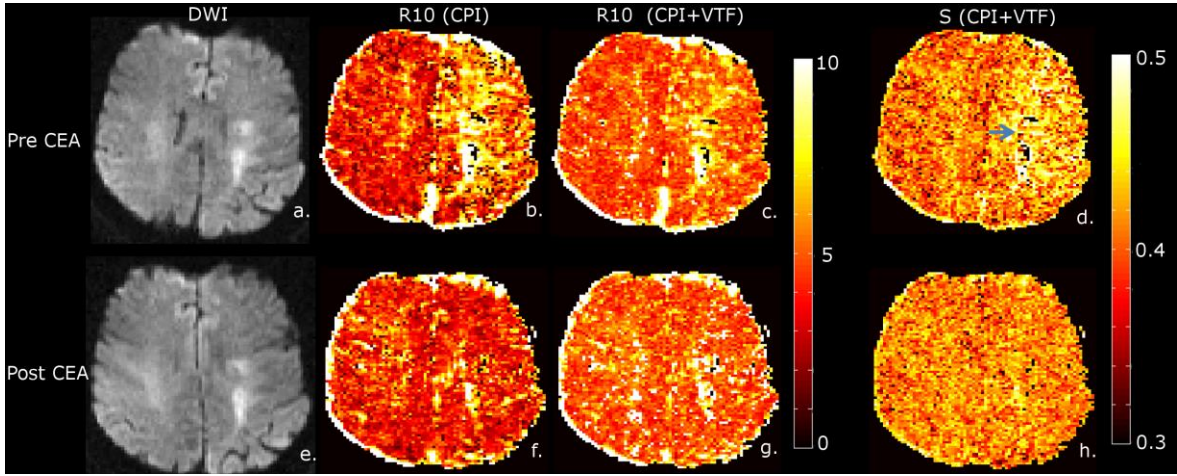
DWI (a, e), $R10$ (b, c, f, g), S (dispersion) (d, h) maps for CPI (b, f) and CPI+VTF (c, d, g, h) showing area of infarction (from DWI) with higher values of $R10$ with both CPI and CPI+VTF. b) $R10$ with CPI also showed higher values in left MCA territory which improved post-CEA (f). c) $R10$ with CPI+VTF showed much reduced values in left MCA territory where high amount of dispersion was found (marked with arrow in d.). Dispersion was found to completely decrease post-CEA (h).
